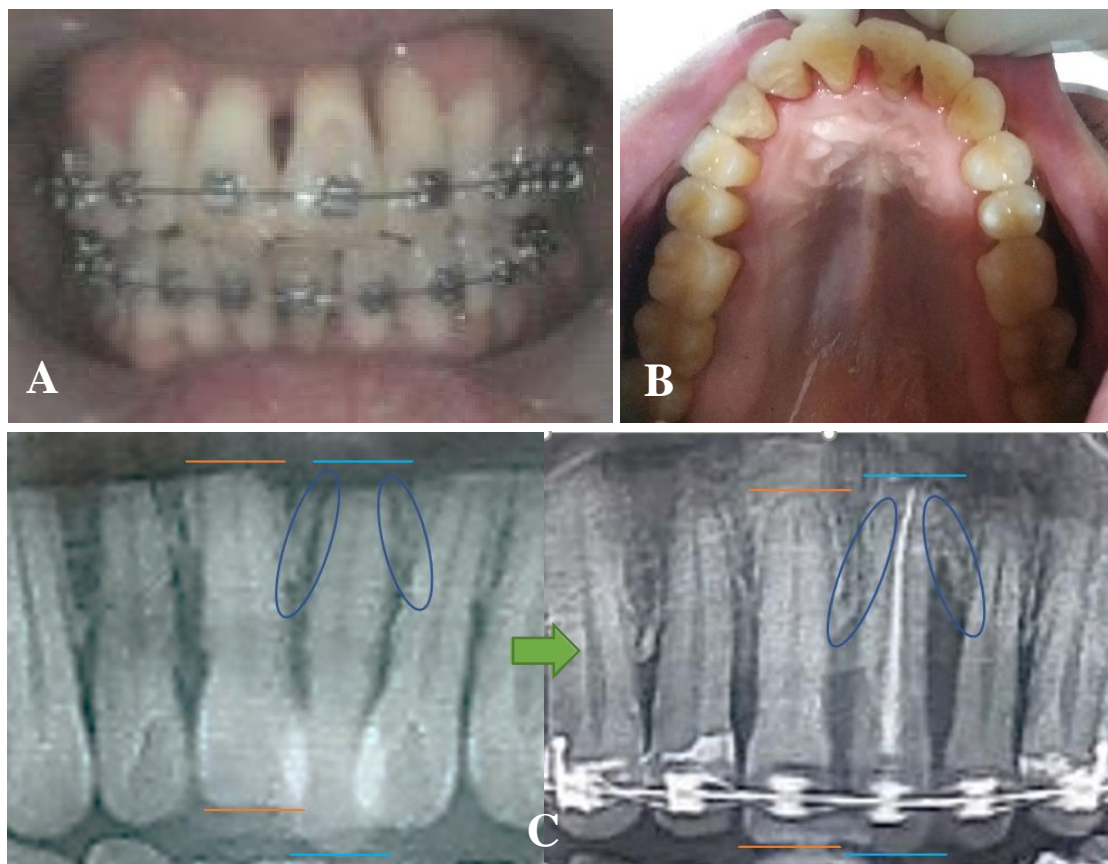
Orthodontic treatment intraoral facial view (A), aligned teeth after debonding (B), and pre- and post-orthodontic radiograph comparison showing intruded left central incisor (blue line on incisal plane was levelled with orange line) and increased density of surrounding alveolar bone (inside the blue circles) (C).
